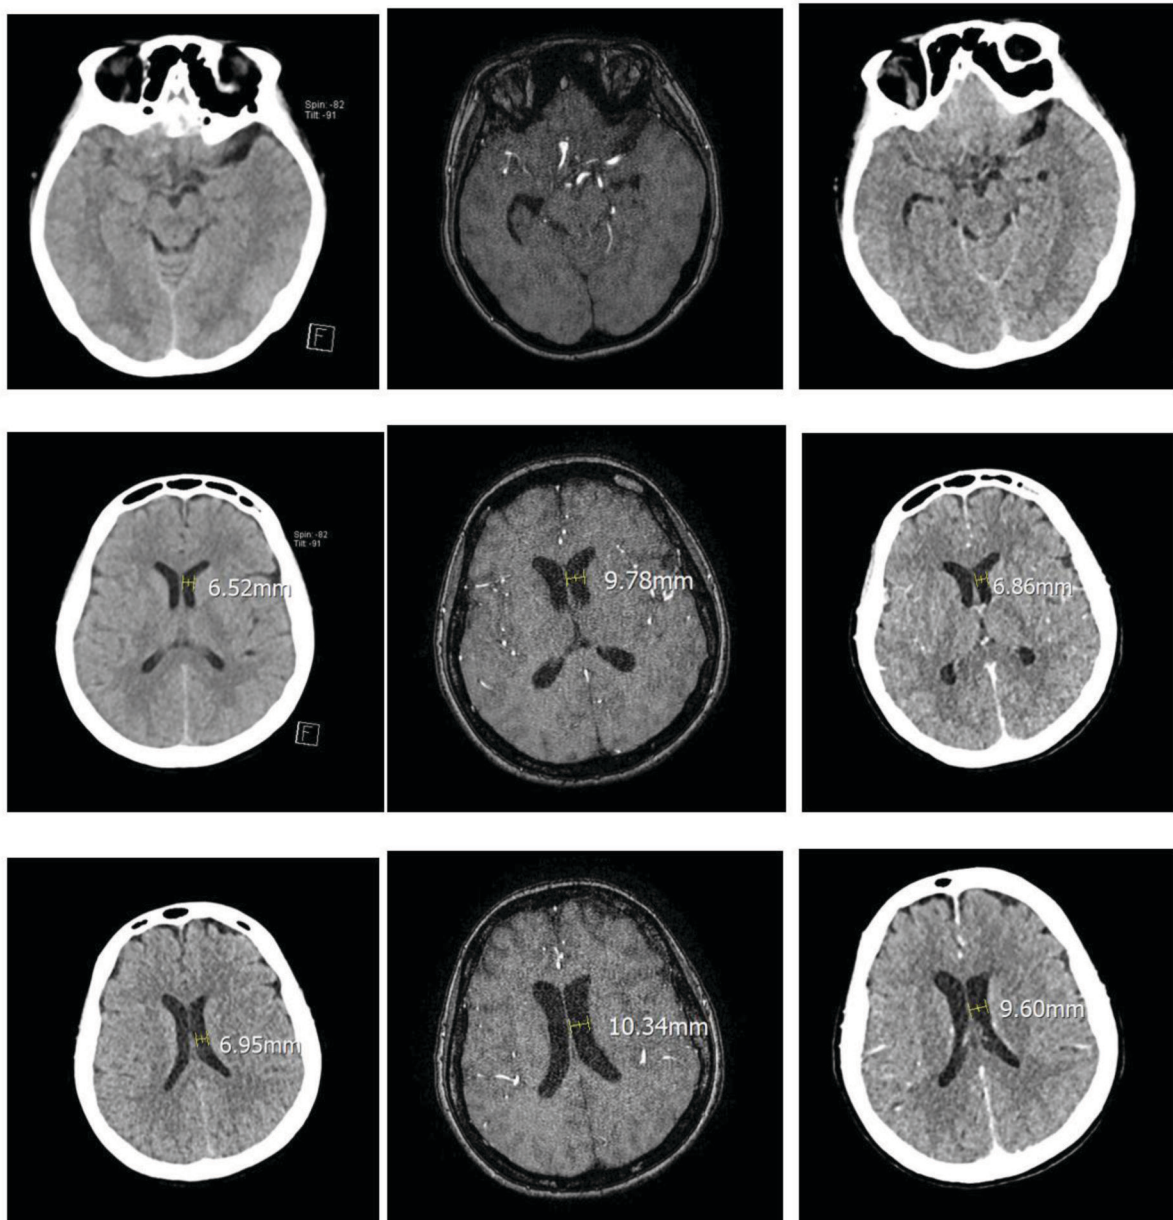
CT Brain Non-contrast (01/04/2023) vs MRI-MRA Brain (03/04/2023) vs CTA Brain (05/04/2023)
